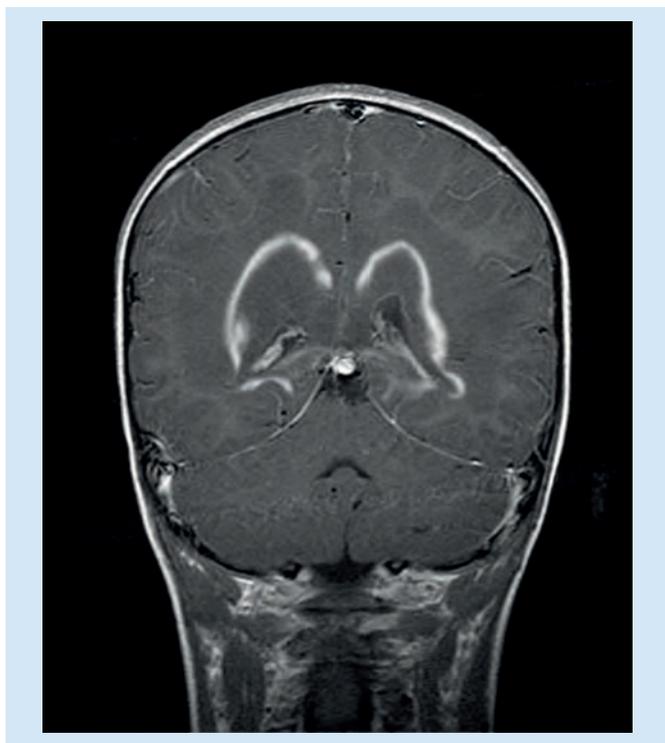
MRI in X-linked adrenoleukodystrophy. Contrast enhancement around a bilateral zone of white matter.
